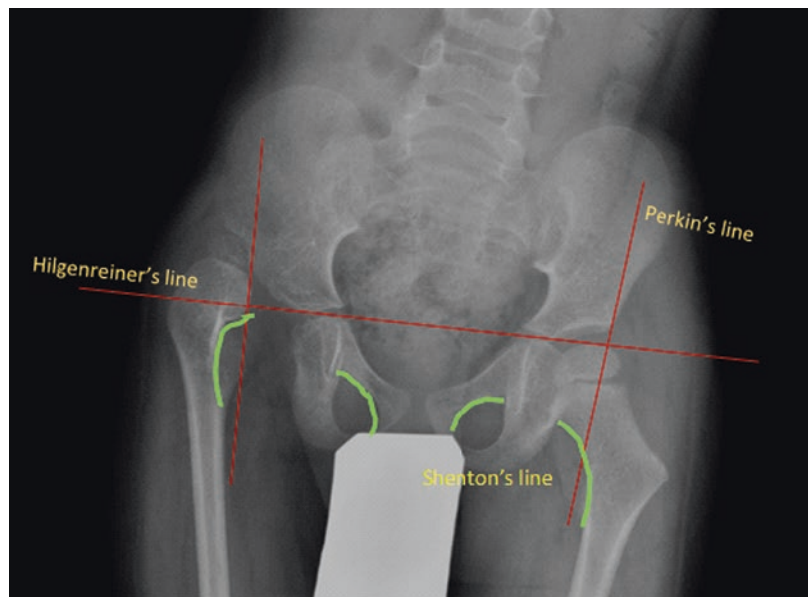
X-ray showing Hilgenreiner’s, Perkin’s, and Shenton’s lines. The right femoral head is in the upper outer quadrant, hence dislocated
